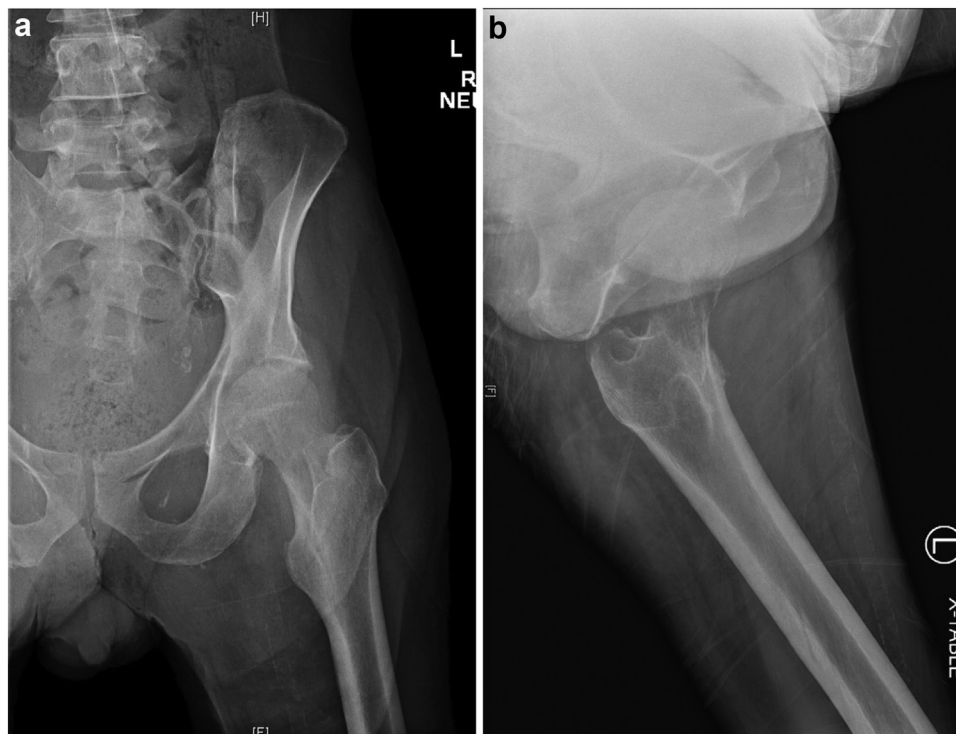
Preoperative radiographs. Anteroposterior (a) and lateral (b) radiographs of the left hip demonstrating significant lucencies of the femoral head and neck.
